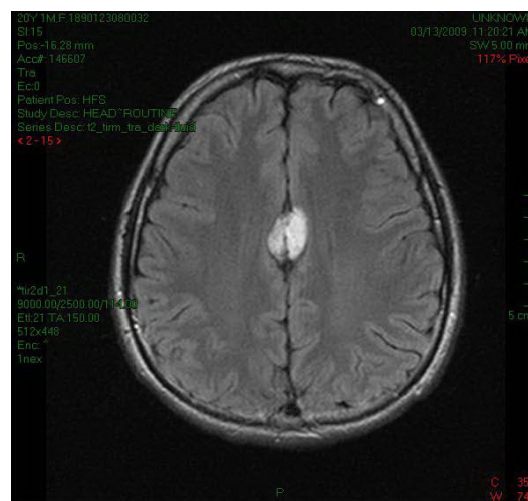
Interhemispheric lipoma on MRI transversal section (T2)
